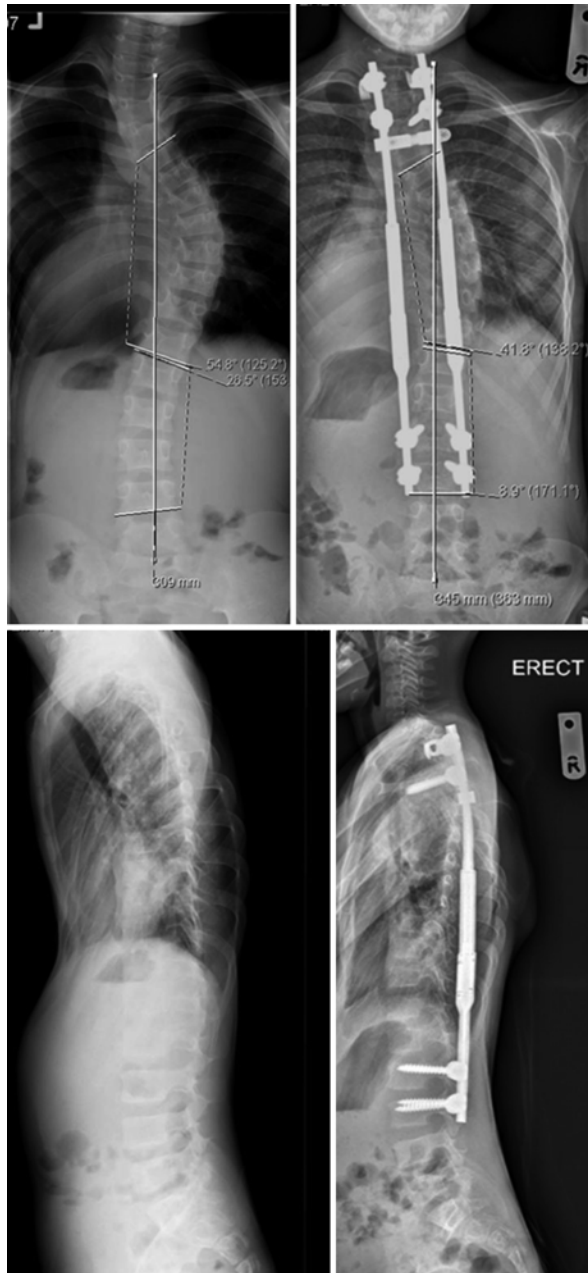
A 7 year old Marfan syndrome boy with juvenile scoliosis and pectus excavatum treated with a novel magnet driven growing rod (MdGR) implant – dual rod insertion. Preoperative and postoperative PA and lateral radiographs are shown
